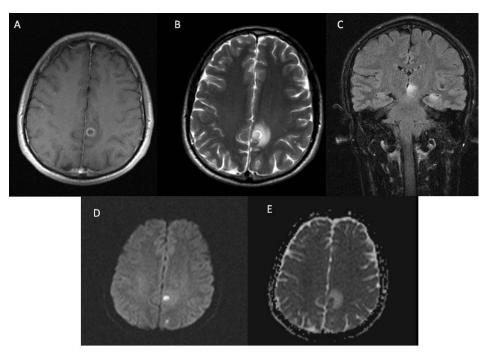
First cranial MRI: A) Ring enhancing lesion with internal hypointensity on the left medial occipital lobe next to the interhemispheric fissure on T1-weighted magnetic resonance images with gadolinium injection, B-C) T2-weighted and FLAIR sequences revealed another nodular occipital and a left diencephalic lesion, D-E) DWI and ADC map revealed central hyperintensity on DWI B1000 with hipointensity on ADC for occipital lesions.
